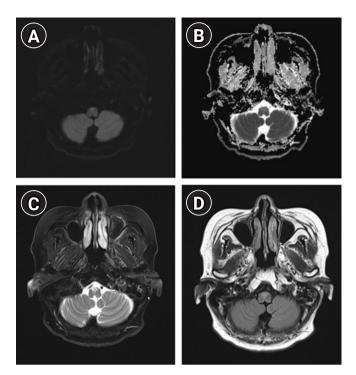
Magnetic resonance imaging (MRI) findings at 10 months after symptom onset. Follow-up brain MRI revealing a normalized diffusion-weighted image (A) and apparent diffusion coefficient (B) sequence on both the anteromedial medullar and cervical spinal cord with decreased perilesional signal intensity on T2-weighted (C) and T2-weighted fluid-attenuated inversion recovery (D) sequences, 6 months after completion of infliximab treatment.
